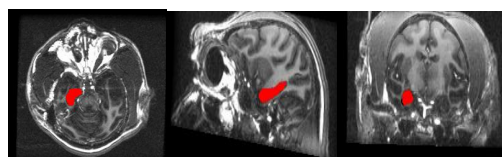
Location of the hippocampus (red) in a MRI. The axial (left), sagittal (middle), coronal (right)
